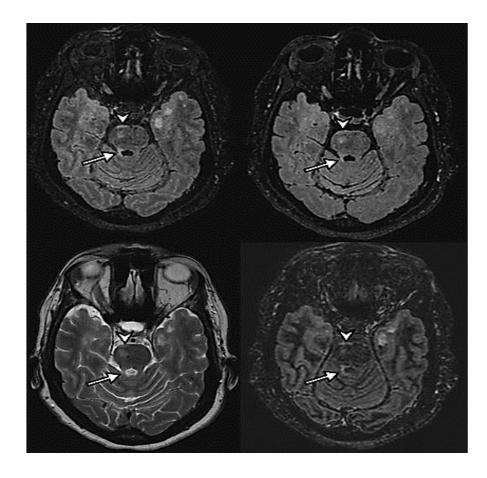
MRI BRAIN OF MULTIPLE SCLEROSIS
